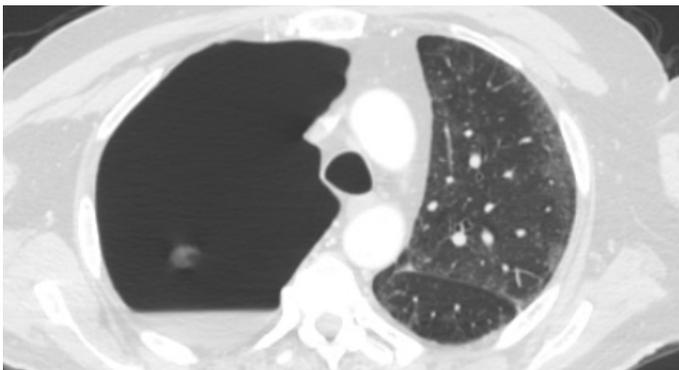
Pneumothorax is seen at both chest XR and thorax CT.
